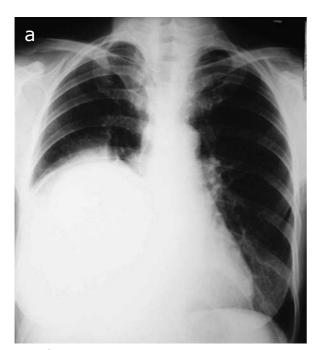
Chest X-ray and CT scan of the chest reveals a giant mass, shifting the mediastinal structures to the left
